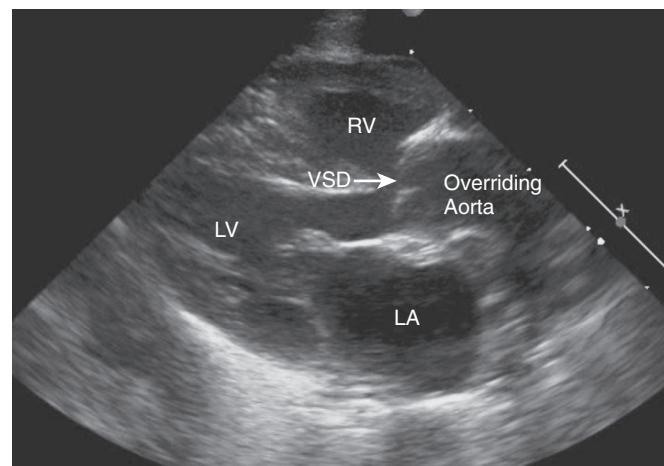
Parasternal long-axis view on echocardiogram of a newborn infant with tetralogy of Fallot. The right ventricle (RV) is anterior, and left ventricle (LV) is posterior, with a large ventricular septal defect (VSD) and overriding aorta. LA, Left atrium.
